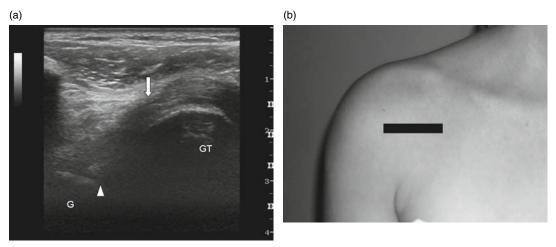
Anterior labrum: (a) ultrasound image in the long axis of the subscapularis muscle demonstrating the anterior labrum (arrowhead) deep to the subscapularis tendon and (b) the corresponding transducer position. LT, lesser tuberosity; G, glenoid.
